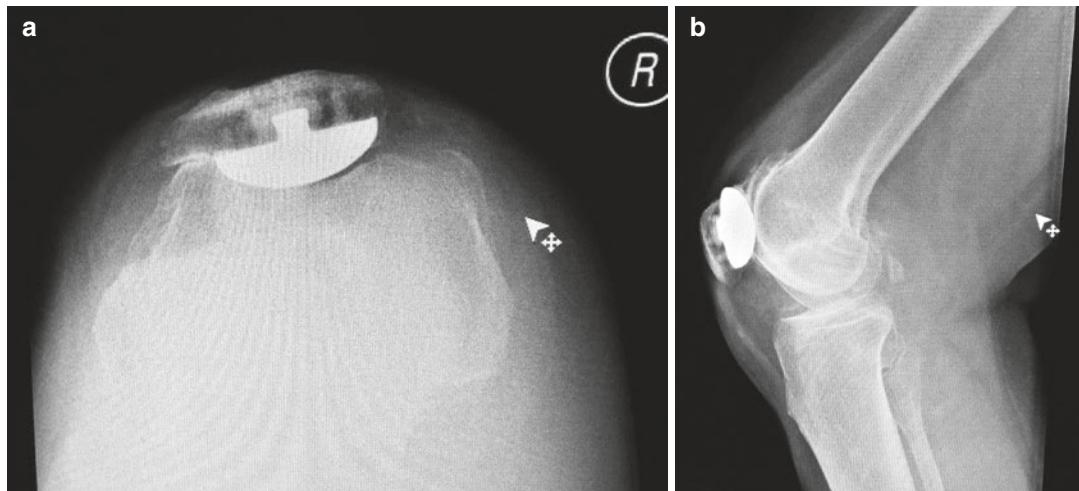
Radiographs of failed metal patella replacement with erosion of the femoral sulcus. (a) Merchant view, (b) lateral view
